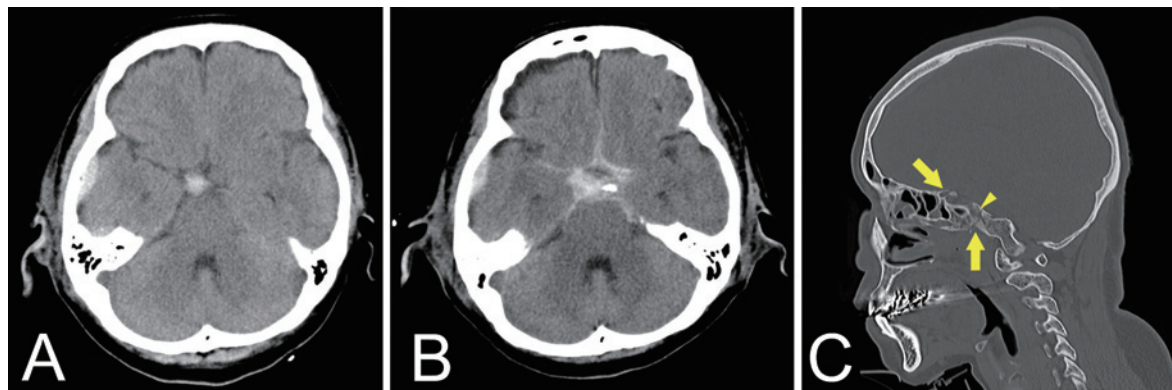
Axial view of computed tomography at the time of hospital arrival (A) and at the time of rebleeding (B) shows a hematoma confined to the suprasellar region that has changed to a diffuse subarachnoid hemorrhage. Sagittal view of computed tomography at the time of hospital arrival (C) shows skull base fractures (yellow arrows) and posterior clinoid process fracture (yellow arrowhead).
